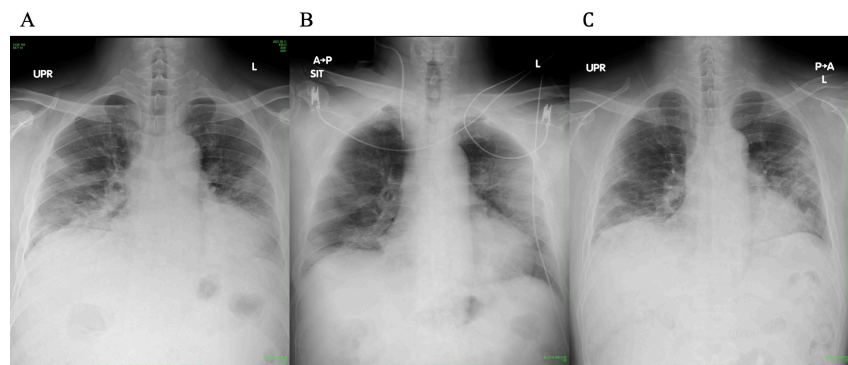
A: On admission, an x-ray scan of the patient's chest showed a ground glass shadow bilaterally in the lungs; B: At the time of transfer to the ICU, an x-ray scan of his chest showed deterioration of the left lung field; C: Before discharge, an x-ray scan of his chest still showed an infiltrative shadow in the lungs bilaterally.
